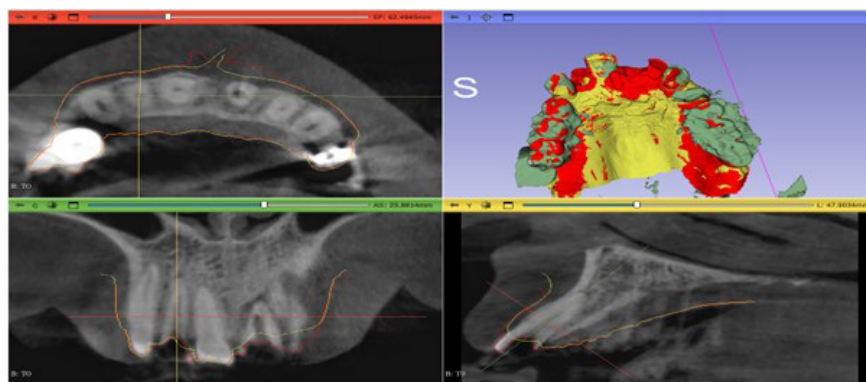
3D Slicer Software Analysis of Soft Tissue Dimension Changes in Pre and Postoperative CBCT Scans.
